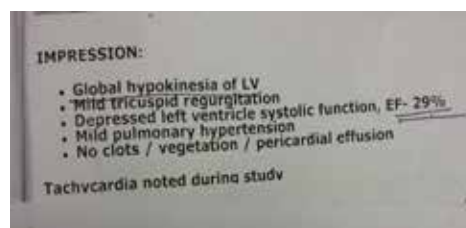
2 D echocardiograph.
